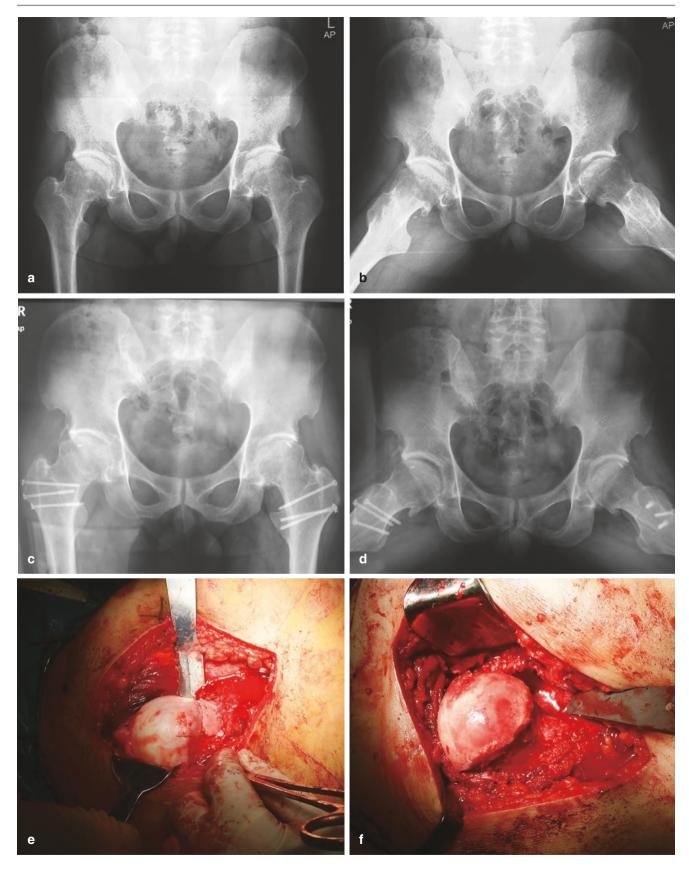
X-ray manifestation and in-operation photos of Case 1. (a,b) X-ray posteroanterior radiograph and Dunn view; (c) X-ray radiograph20 months postoperative right hip; (d) X-ray radiograph
